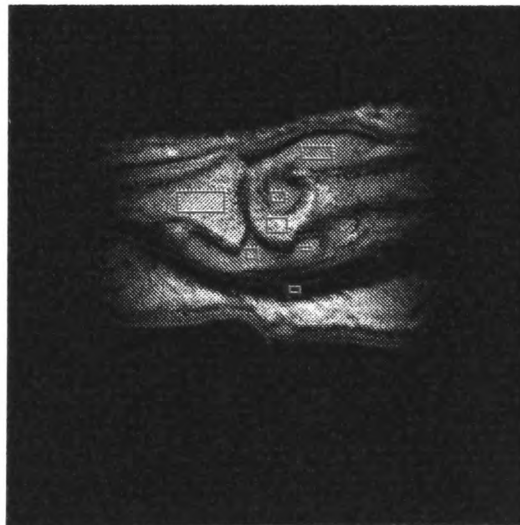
MRI finger scan with rectangles drawn in the proximal phalanx, middle phalanx, tendon, hole, joint space, synovium dorsal and synovium palmar.
